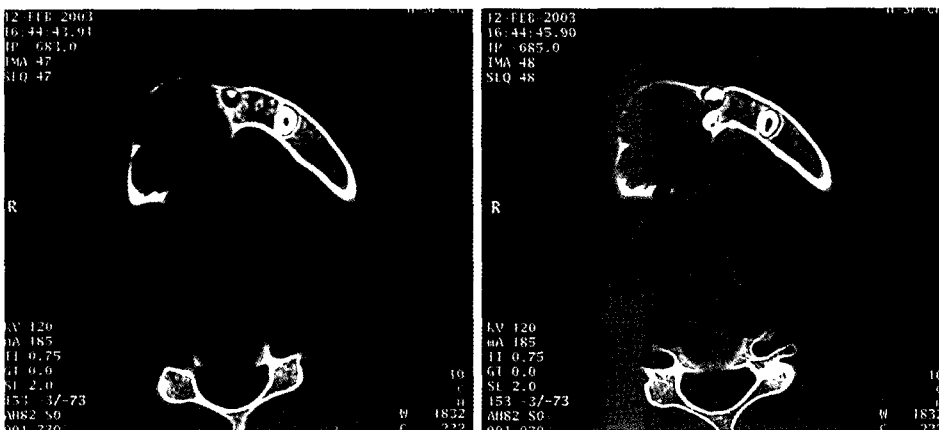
Computed tomograph reveals a well-demarcated, unilocular cystic appearance with partial resorption of the lingual cortical bone.
